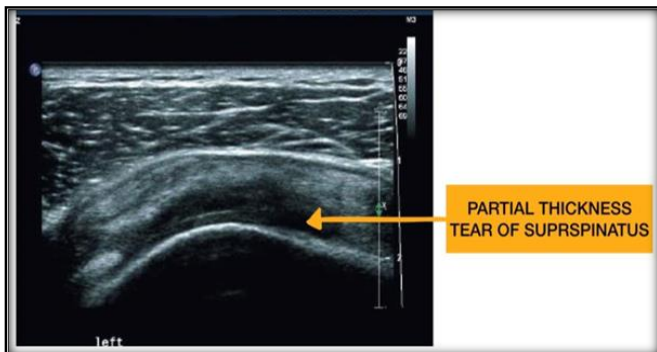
A 46 year old male with right shoulder pain, diagnosed to have partial thickness tear of supraspinatus tendon. Image - Grayscale ultrasound short axis view showing partial thickness tear of supraspinatus tendon.
